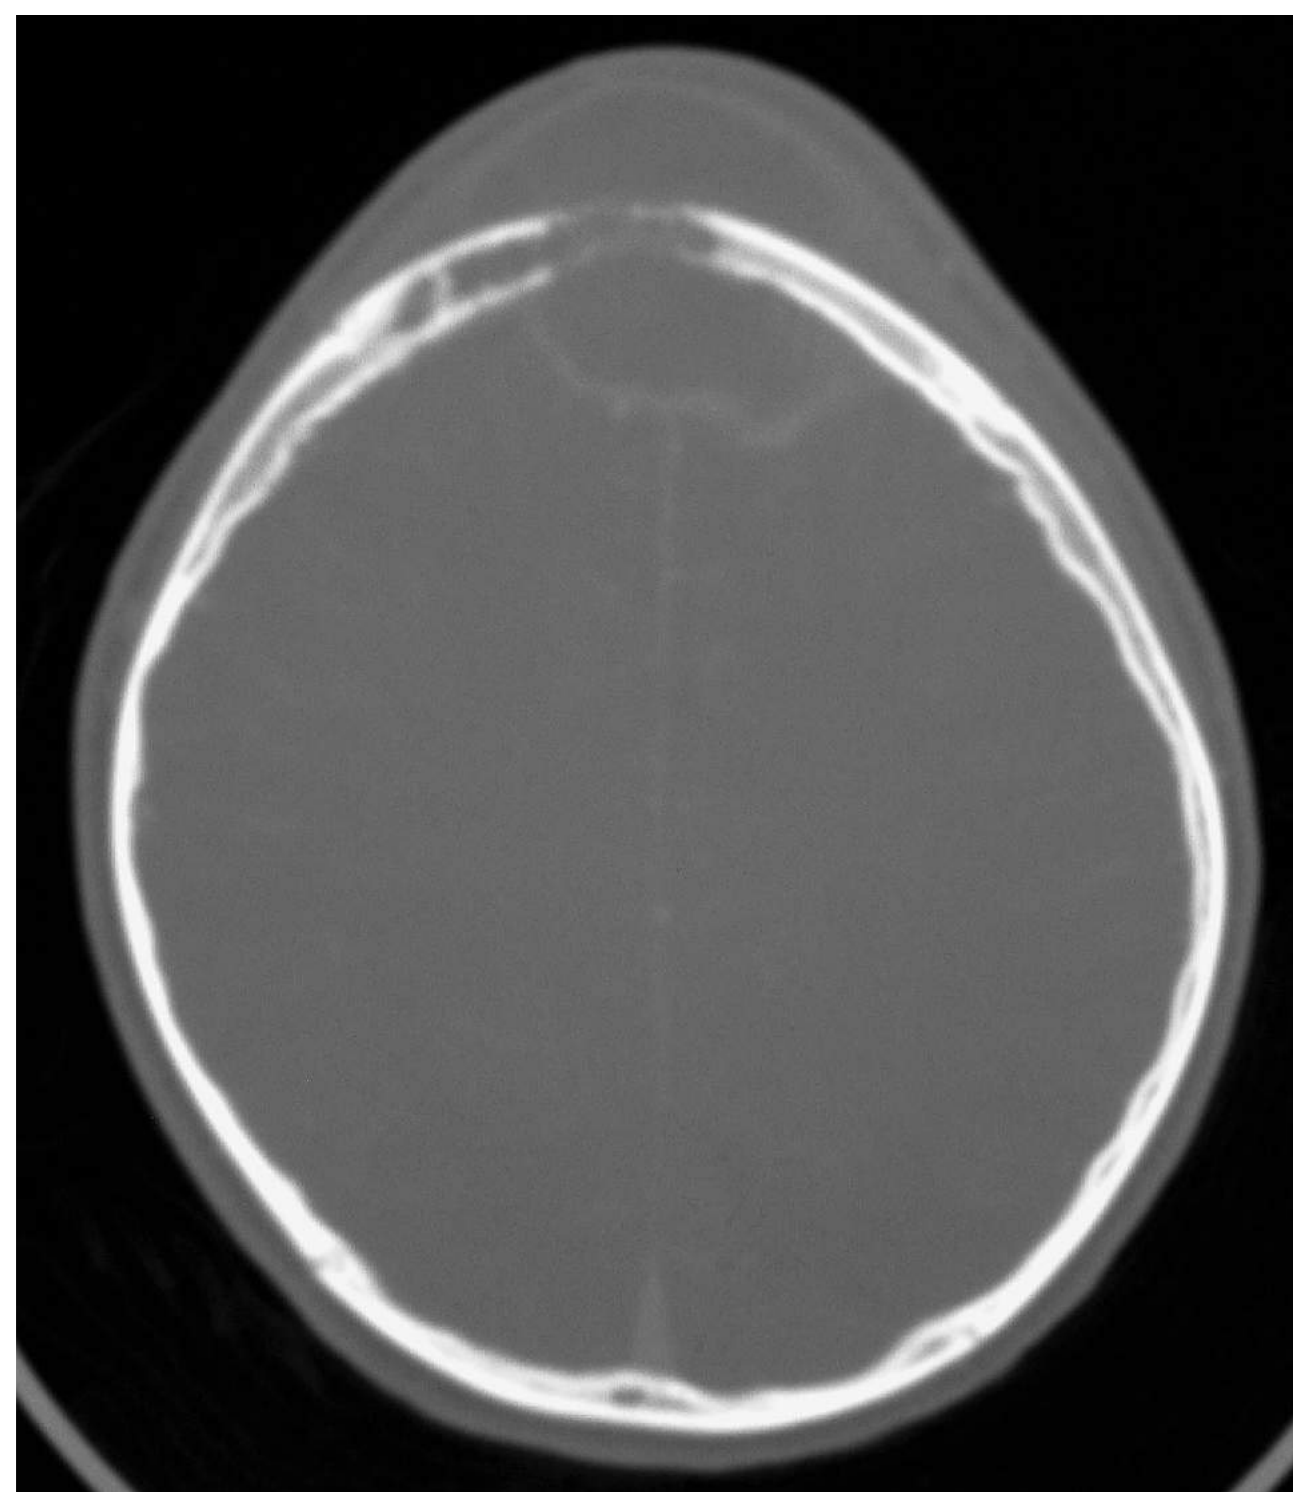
■ Sinusitis—Pott’s Puffy Tumor. CT (bone window) highlighting bony destruction of inner and outer table of frontal bone from sinusitis. (Photo contributor: David Effron, MD.)
